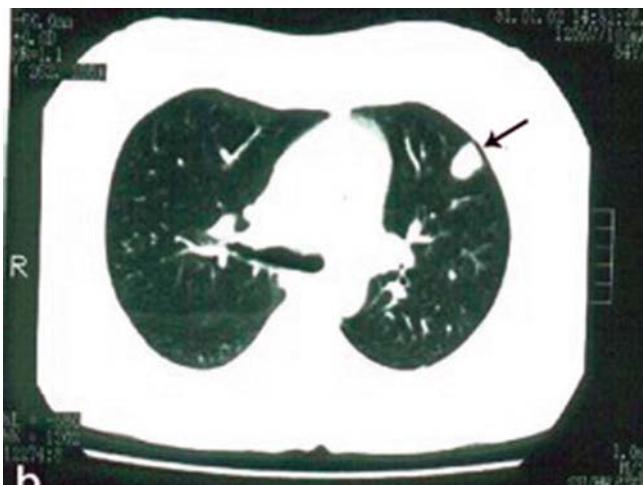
CT of chest depicting a sharply defined 1.5 cm solitary nodule in the left upper lobe (arrow) (Courtesy of Dr. Ufuk Cagirisi, Ege University Medical Faculty, Izmir, Turkey). With permission from *Interact Cardiovasc Thorac Surg*, see chapter references for complete citation.
